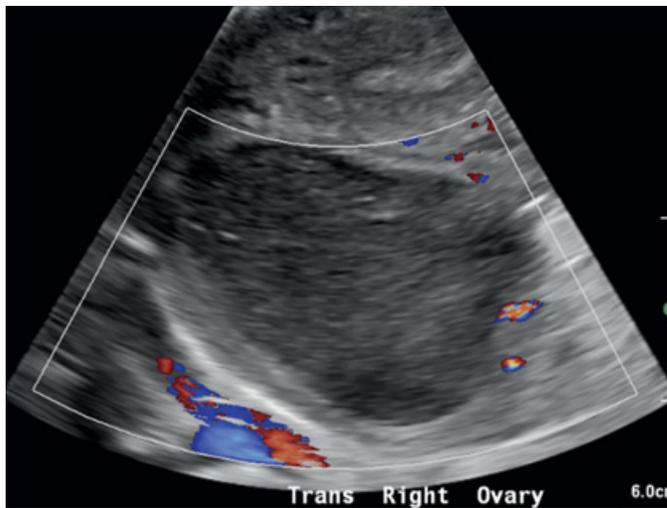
Characteristic ultrasound appearance of endometrioma with diffuse homogeneous ground-glass echotexture due to hemorrhagic debris. (Photo courtesy of Thomas Stoecker MD.)
